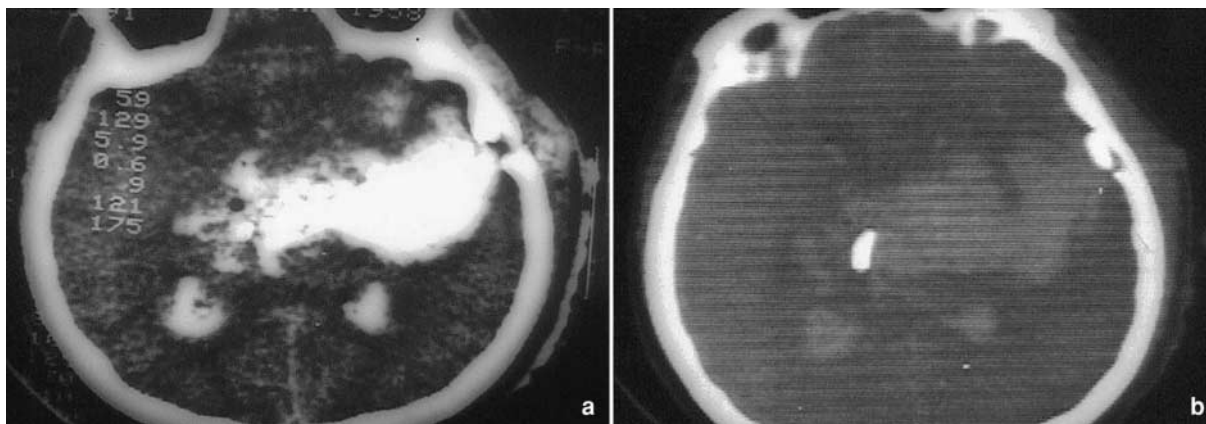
(a) Brain CT scan shows a bone defect at the entry site and the wound canal, which is typically wider near the entry site. Bone fragments and air are located at the end of the wound canal. There is also blood in the lateral ventricles, and diffuse cerebral edema. (b) Wide window brain CT scan at a slightly higher level shows the entry site with a bone fragment from the inner table of the skull. A large bone fragment at the end of the wound canal is now well visualized
